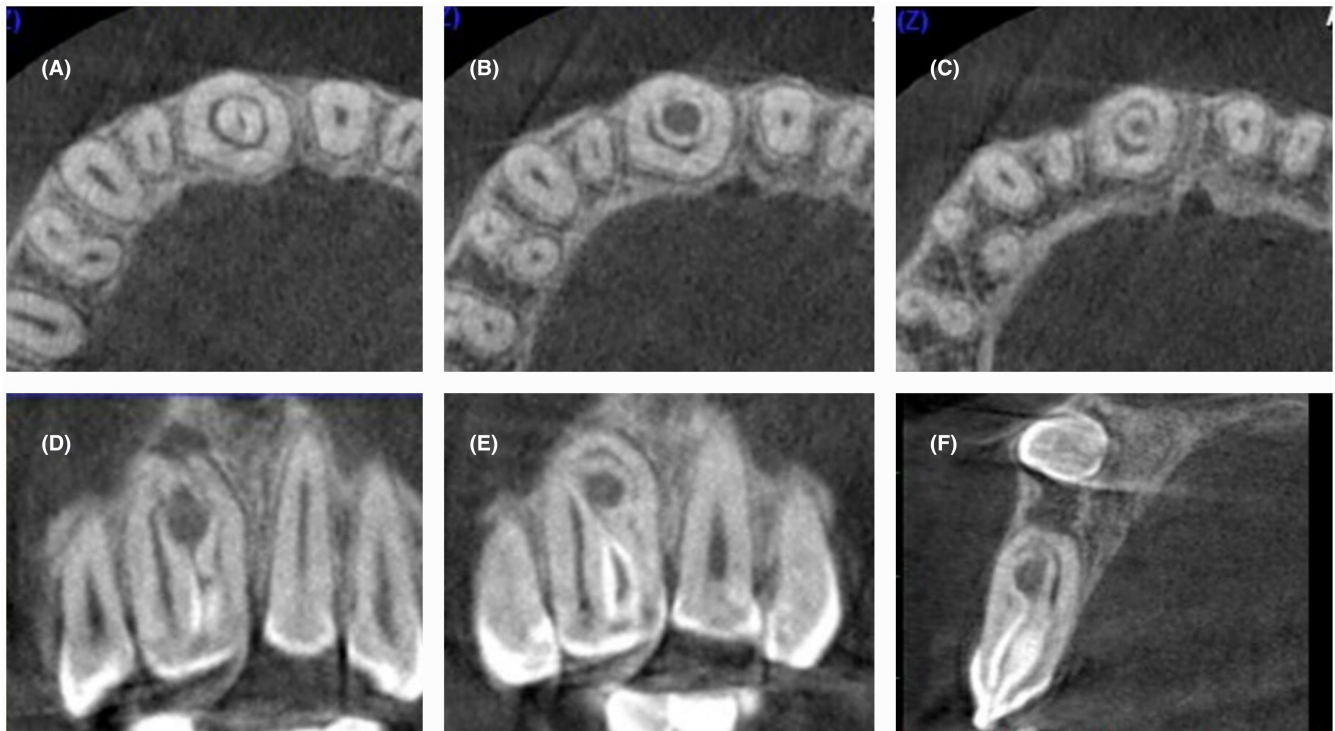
CBCT images revealed type IIIb DI and supernumerary impacted tooth. (A) Coronal region in axial view. (B) Medial region in axial view. (C) Apical region in axial view. (D) and (E) Coronal view. (F) Sagittal view.
